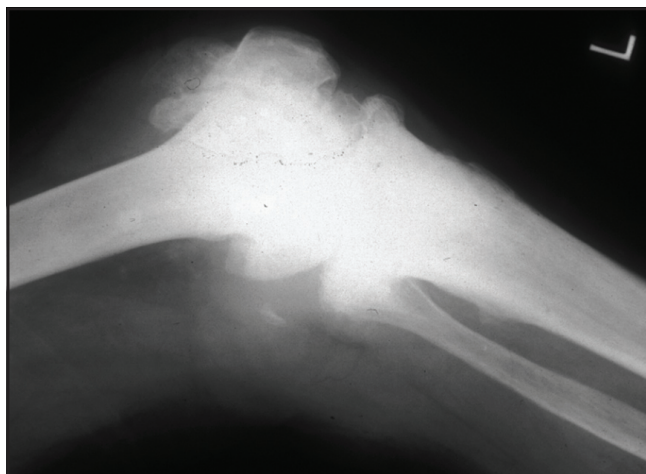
X-Ray of Charcot's Knee Joint
